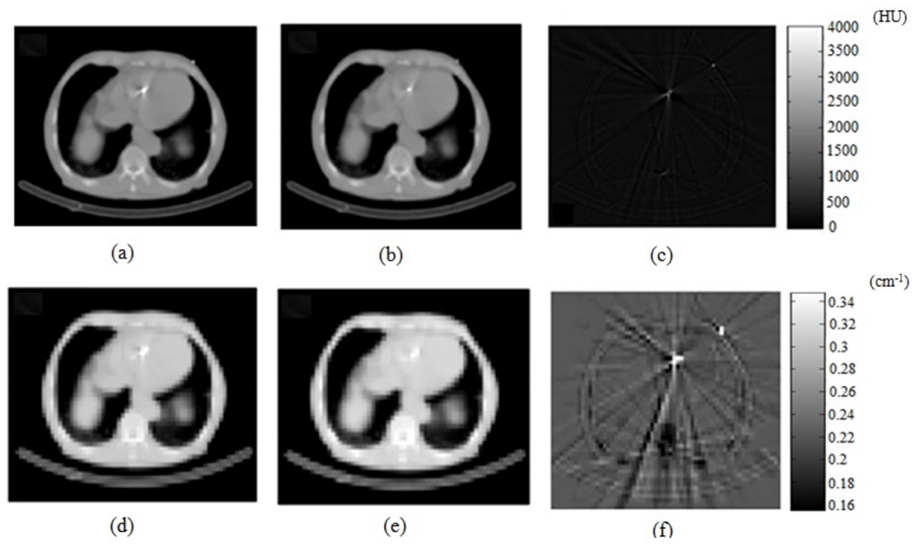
Typical transverse slice of patient with ICD lead, (a): CT image reconstructed without MAR, (b): CT image reconstructed with MAR, (c): difference image between CT images, (d): μ -map generated without MAR, (e): μ -map generated with MAR, (f): difference image between μ -maps.
